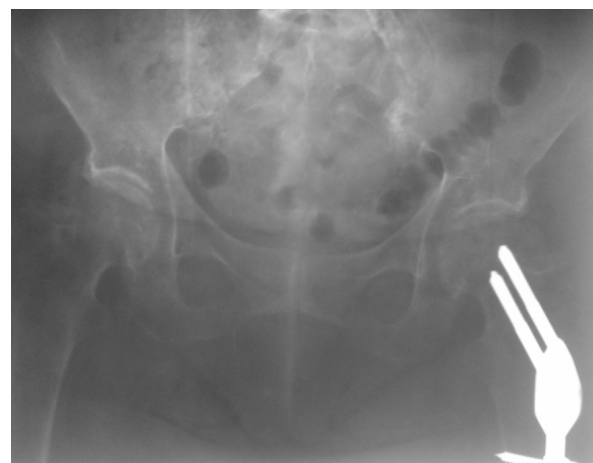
X-ray of pelvis and hips with implanted osteosynthesis material after left femoral fracture
